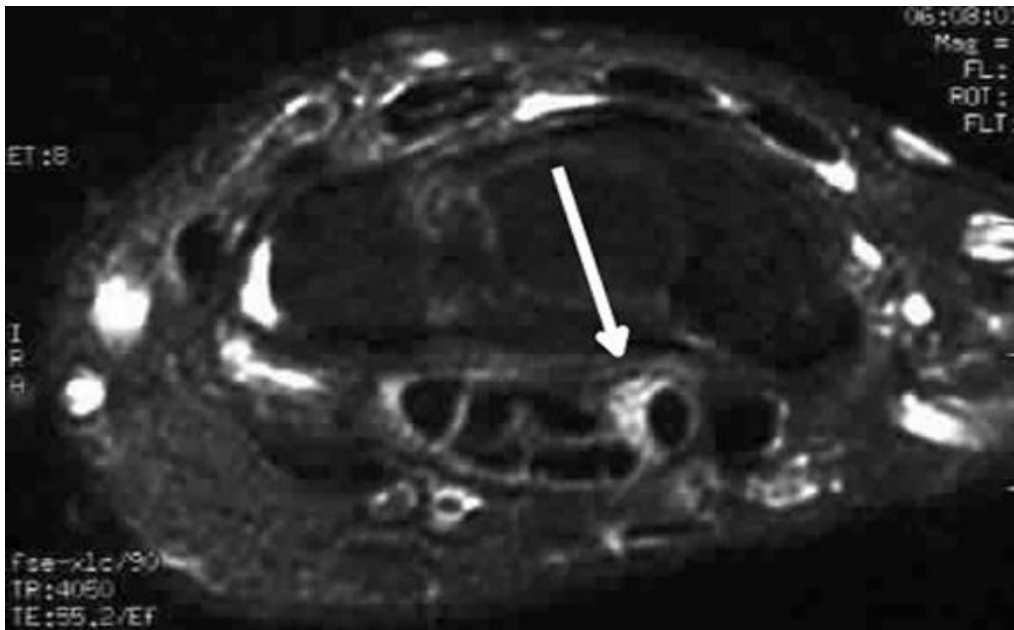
Axial fast spin-echo T2-weighted MRI scan of the median nerve (shown by the arrow) within the carpal tunnel
